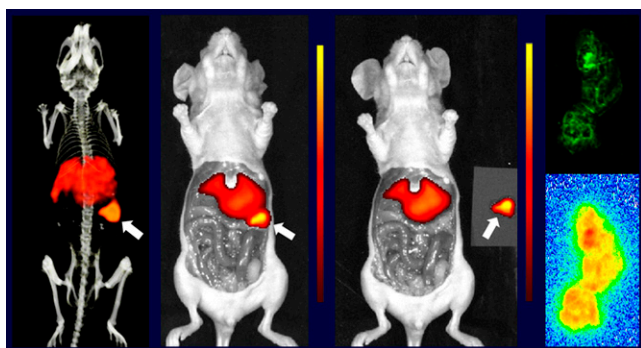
SPECT/CT and near-infrared (NIR) renal imaging with ^{111}In -G250-IRDye800CW targeting carbonic anhydrase IX. Left to right: SPECT/CT, NIR imaging, and NIR imaging postsurgery. Far right: Top, ex vivo NIR; bottom, ex vivo autoradiography.
